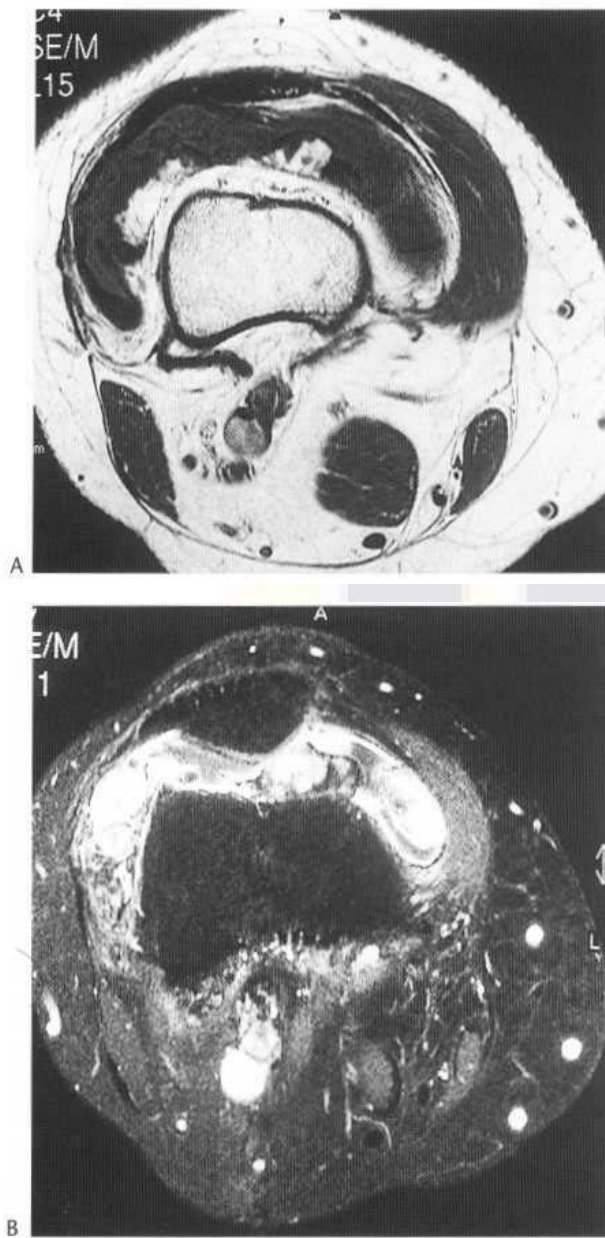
Pigmented villonodular synovitis of the knee joint. Axial T₁-weighted (A) and T₂-weighted fat-suppressed (B) MR images through the patella and suprapatellar recess showing a heterogeneous mass within the joint made up of fat, haemosiderin, fibrous tissue and cellular elements.
